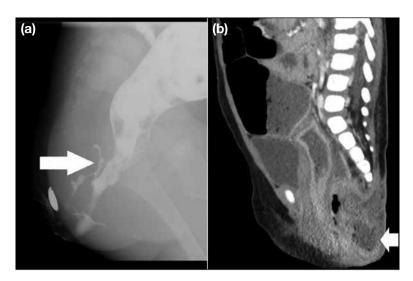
Leakage from suture line. This female patient presented with anovestibular fistula with a low-type anorectal malformation at age 1 year. She was discharged from the hospital after undergoing perineal anoplasty. Then, her buttocks began to swell because of an abscess. Colonography showing the presence of a fistula extending from the suture line to the skin. She underwent colostomy and antibiotic therapy was initiated. (a) Lateral radiograph with colonography using barium showing anorectal cutaneous fistula extending from the suture line (arrow). (b) Sagittal reformatted contrast computed tomography showing a low attenuation area surrounding an enhanced rim posterior to the rectum (arrow). In this lesion, gas was detected, and an abscess was identified.
